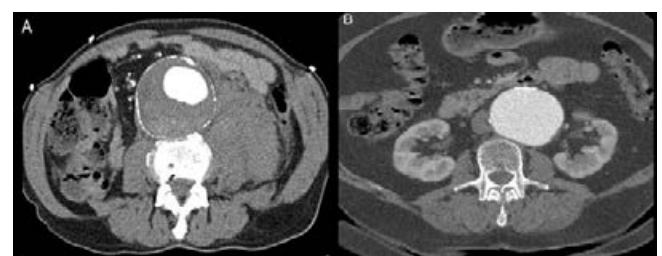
CT of a 7.62 cm atherosclerotic AAA with thrombus; Figure 2B: CT scan of a 6 cm atherosclerotic AAA without thrombus with calcification in the anterior aortic sac wall.
